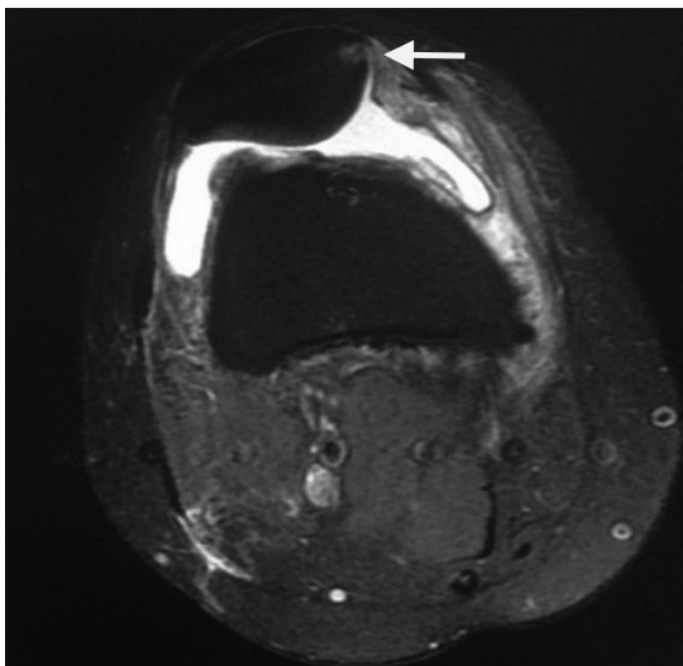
After previous acute patellar dislocation, axial MRI evaluation of MPFL injury from the place of patellar adhesion (yellow arrow). MPFL: medial patellofemoral ligament; MRI: magnetic resonance imaging
